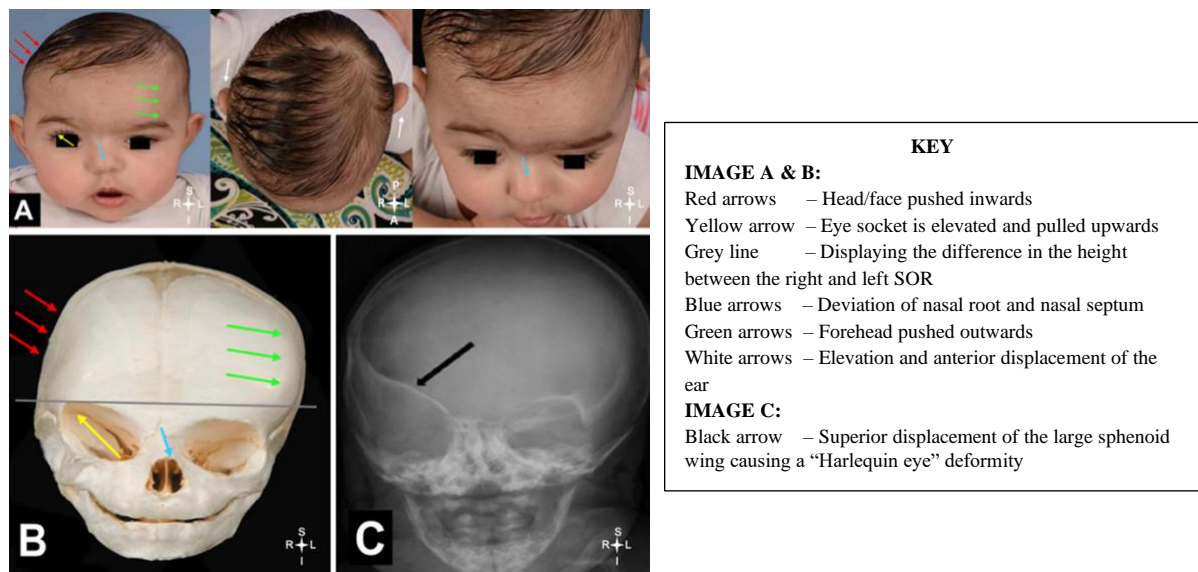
(A) Anterior and superior views of an infant's head with right unilateral coronal synostosis (RUCS) showing the different presentations of ASP in soft tissue. (B) Anterior view of a skull with RUCS showing the different presentations of ASP. (C) Anterior view of an x-ray image showing a typical "Harlequin eye" deformity on the ipsilateral side. (Adapted from Spazzapan *et al.*, 2017 and Brown and Wetz, 2019)
